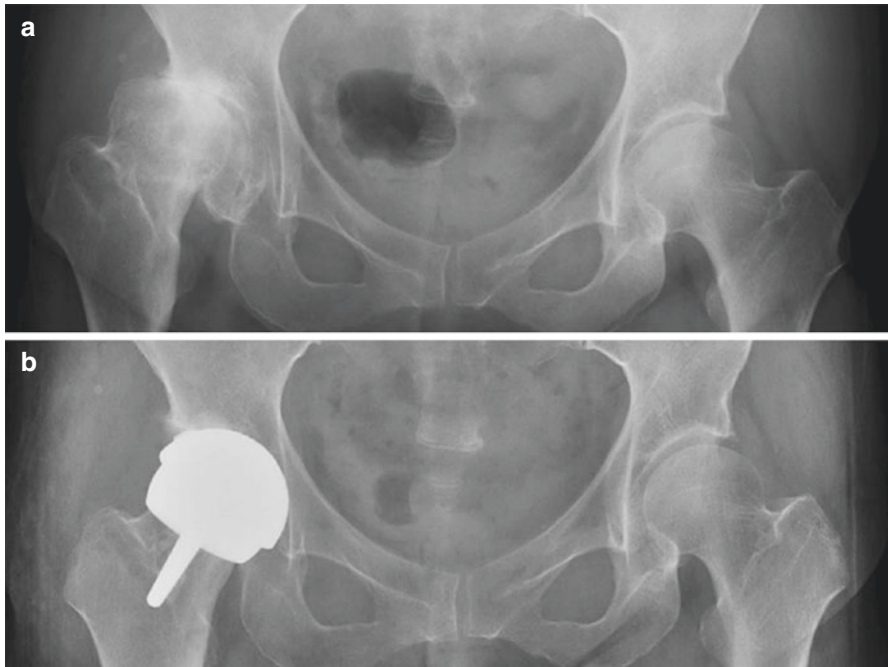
Anteroposterior radiographs of the hip before (a) and after (b) primary total hip resurfacing. A 62-year-old woman with Crowe I developmental dysplasia of the hip (DDH) had total primary hip resurfacing using Birmingham Hip Resurfacing. A 52-mm acetabular cup and a 46-mm femoral component were implanted (these X-ray pictures were agreed by the patients for publication)
